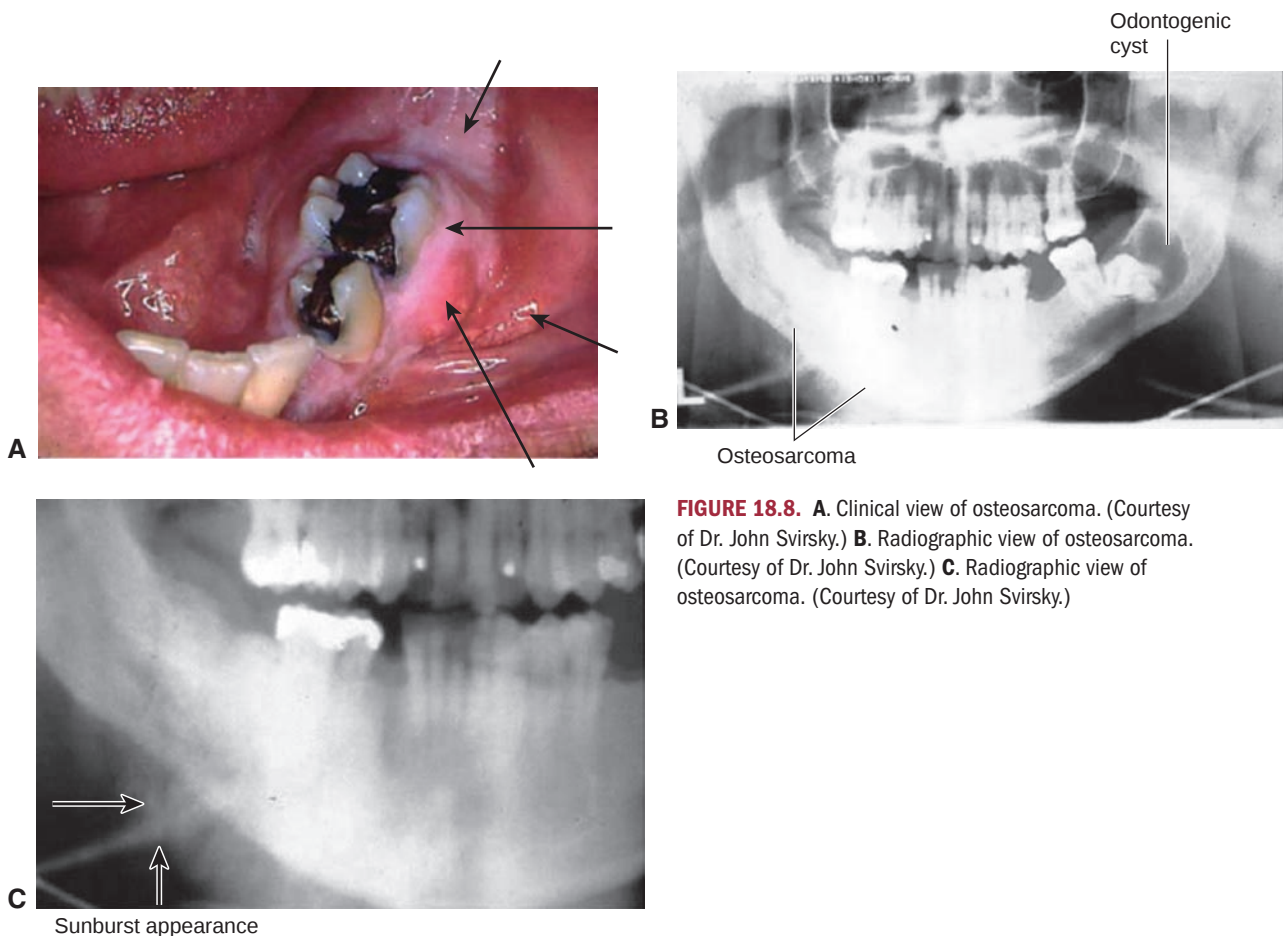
A. Clinical view of osteosarcoma. (Courtesy of Dr. John Svirsky.) B. Radiographic view of osteosarcoma. (Courtesy of Dr. John Svirsky.) C. Radiographic view of osteosarcoma. (Courtesy of Dr. John Svirsky.)
